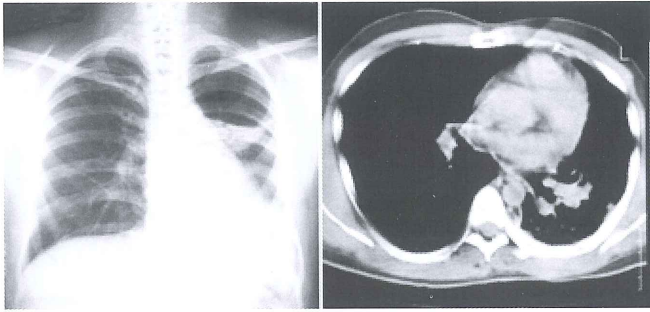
Chest radiography and computed tomography after four years.
